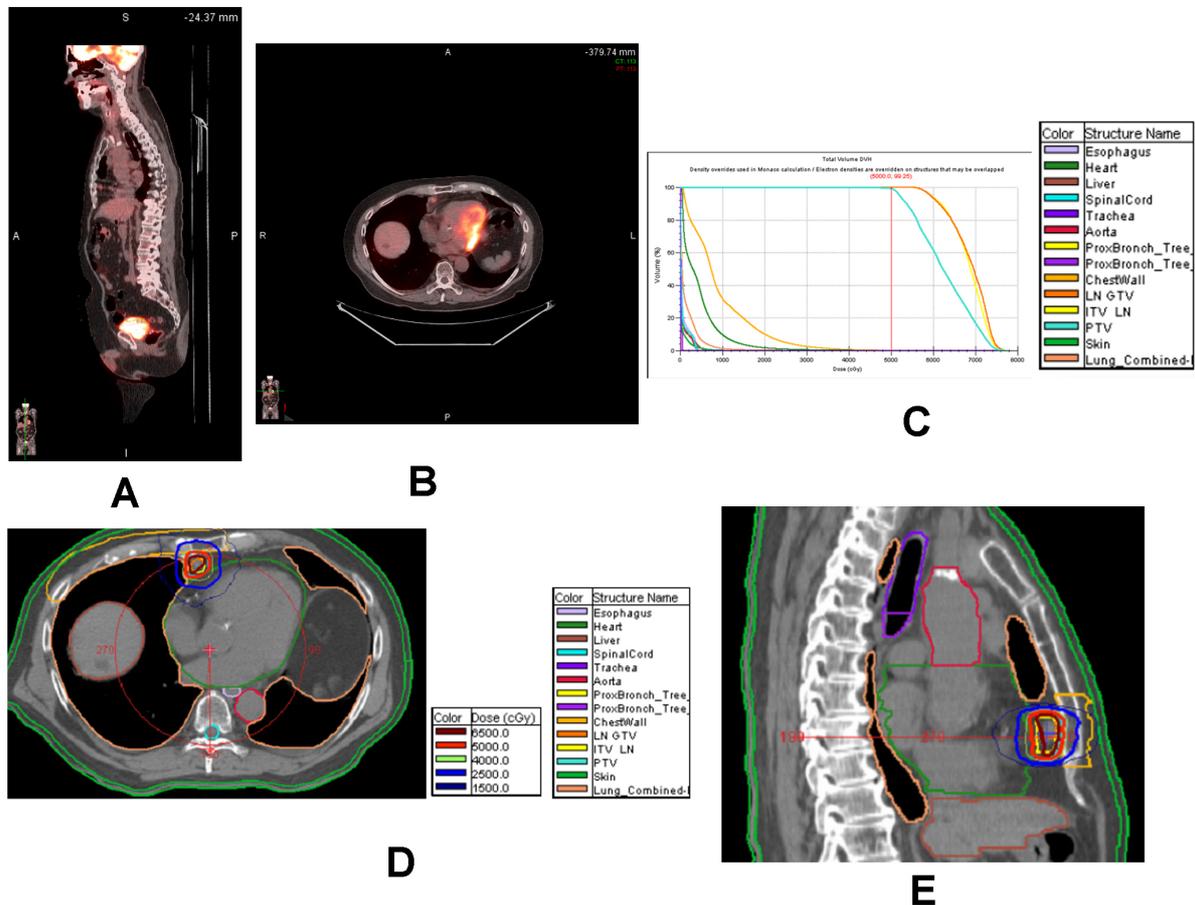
The patient in [Figure 2](#) recurred with an isolated deposit anterior to the heart 1.5 years after initial therapy that was just outside of the previously irradiated field. This recurrence is depicted on PET/CT in (A) sagittal and (B) axial. He was treated with 50 Gy in 5 fractions using a stereotactic body radiation therapy approach in (C) dose-volume histogram; (D) dose distribution in the axial plane; and (E) dose distribution in the sagittal plane, and he remains disease-free 5 years after his initial presentation and 3.5 years after treatment of his recurrence.
